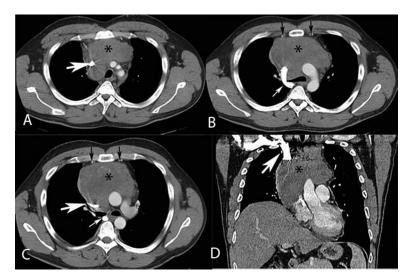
Initial thoracic CT of a 32-year-old man with SVC obstruction secondary to biopsy-proven large B-cell lymphoma. Images were obtained in arterial contrast phase following intravenous administration of 80 mL Omnipaque 350 via the right upper extremity. Figs 1A-C were obtained in the axial plane, and D is a coronal reconstruction. The images reveal a large anterior mediastinal mass (black star, A-D) narrowing of the SVC (thick white arrows, A, C, D), a prominent azygos vein (thin white arrows, B, C) and mild prominence of the internal thoracic veins (black arrows, B, C).
